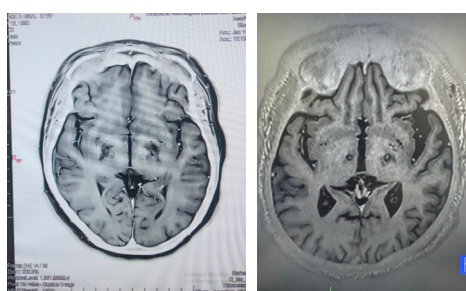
a: T1 W MRI showing bilateral Pallidotomy 2b. T1 W MRI showing right sided PTT lesioning and left sided pallidotomy.
